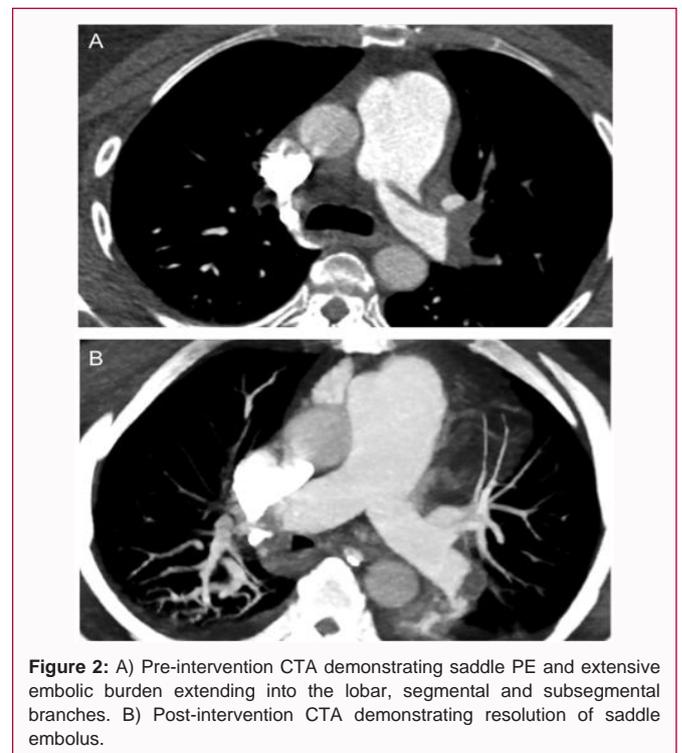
A) Pre-intervention CTA demonstrating saddle PE and extensive embolic burden extending into the lobar, segmental and subsegmental branches. B) Post-intervention CTA demonstrating resolution of saddle embolus.
